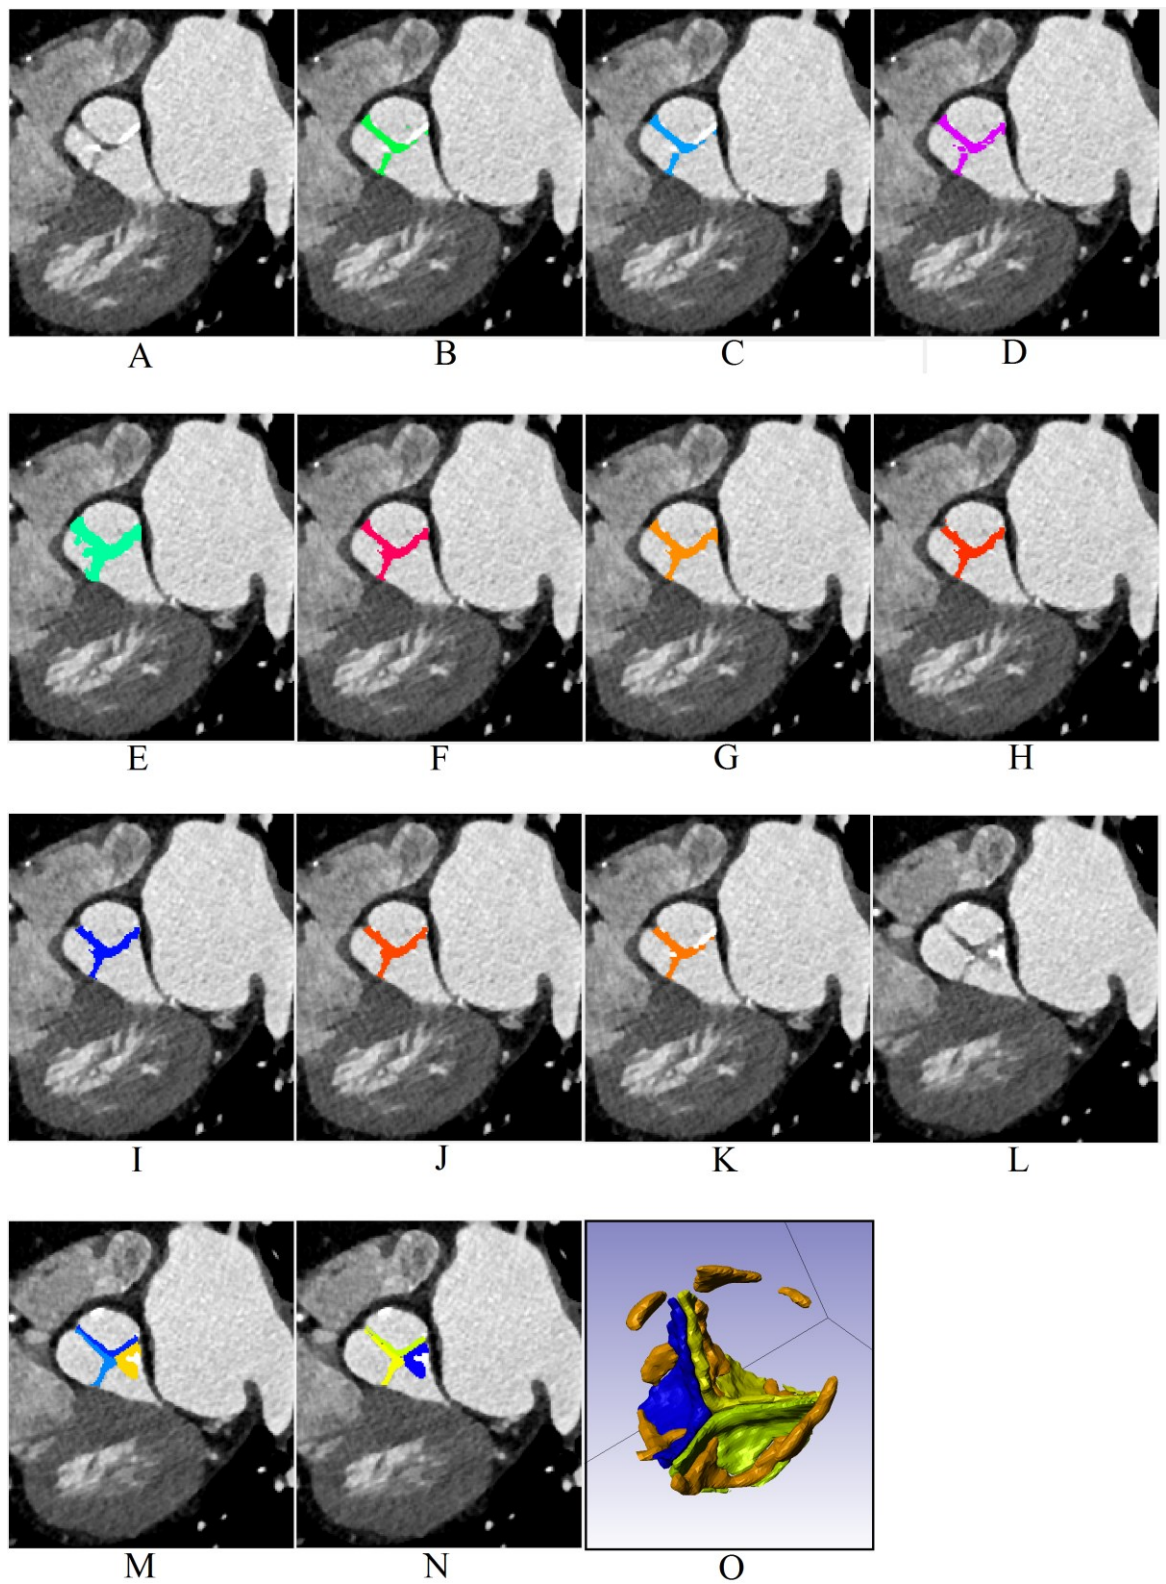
Medical CT images that have the following masks highlighted: No Mask (A), Mask L1 (B), Mask L2 (C), Mask L3 (D), Mask L4 (E), Mask L5 (F), Mask L6 (G), Mask L7 (H), Mask L8 (I), Mask L9 (J), Mask L10 (K), No Mask (L), Mask L11 (M), Mask L12 (N) and a 3D render of the leaflets (O, Mask L12, P4).
